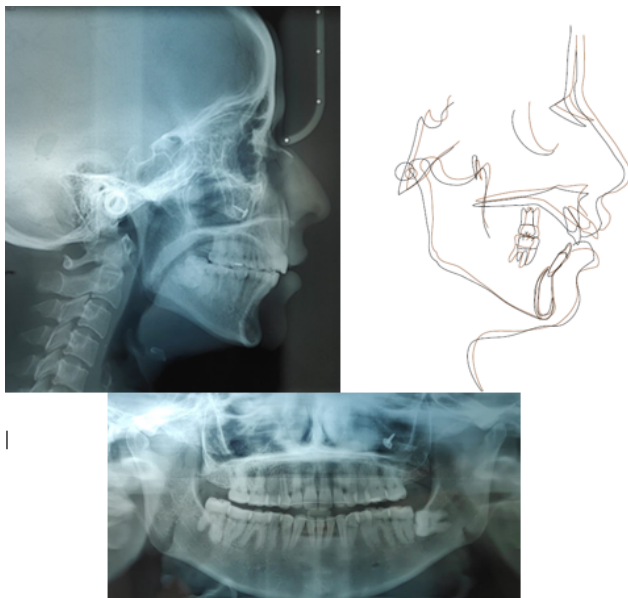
Post Treatment Radiographs and superimpositions.
